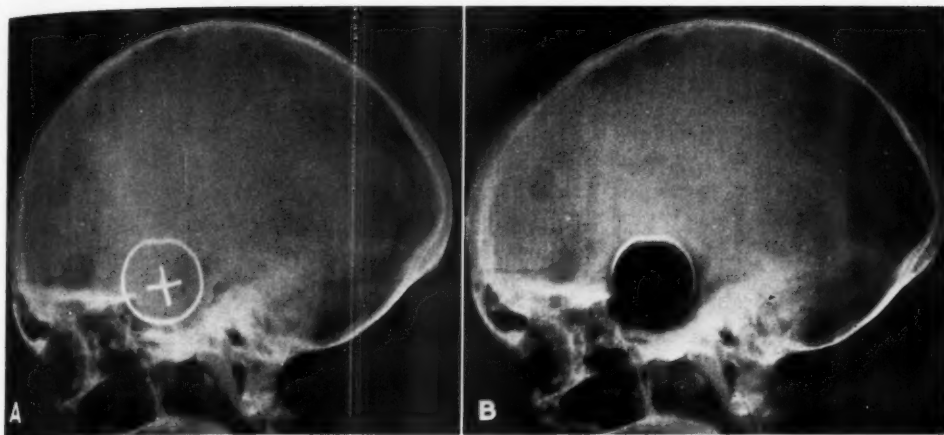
Alignment for treatment of pituitary. A. Roentgenogram taken with auxiliary x-ray tube. The circle and cross are right and left lead markers. B. Accelerator beam added.
